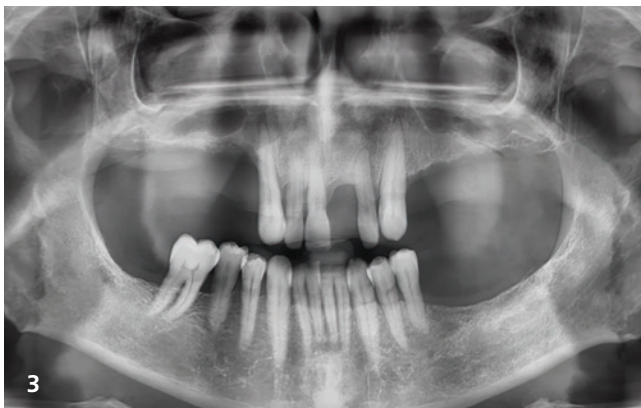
Pre-op dental panoramic tomogram showing bone atrophy of the posterior sextants in the maxillary arch. Fig. 4: Detail of the CBCT scan showing the bone lacuna localised in the maxillary right posterior sextant and a moderate degree of hyperplasia of the sinus mucosa.
